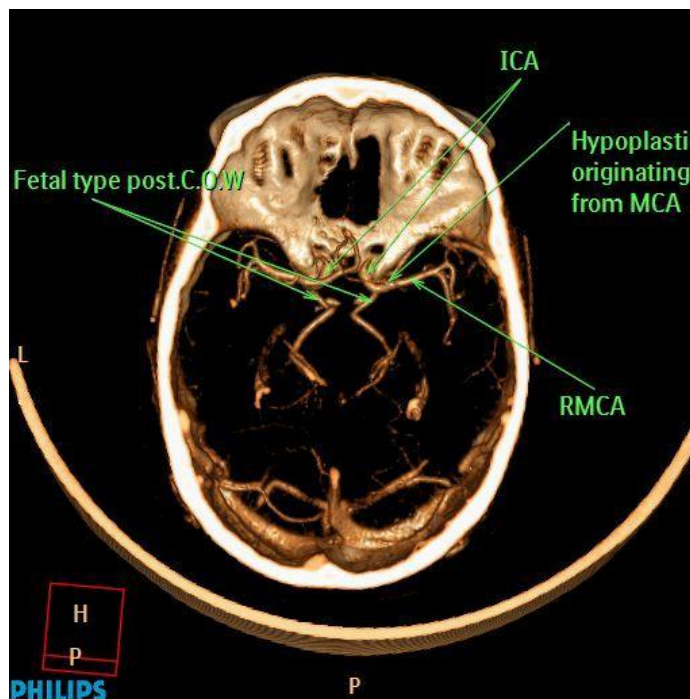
CTA shows bilateral complete fetal type posterior circle of Willis, hypoplastic RA1.
